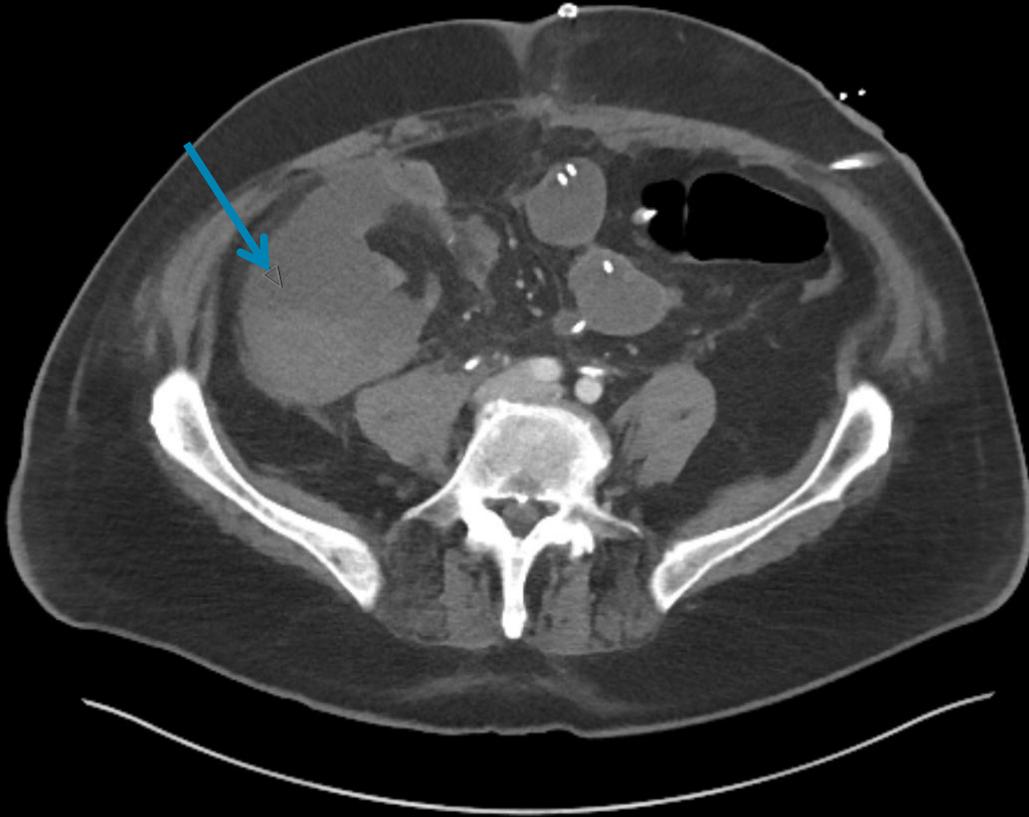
CT abdomen with IV contrast 1 week post neobladder formation. Loculated fluid in the RLQ peritoneal cavity with fluid-debris level indicating a hemorrhagic seroma (blue arrow).
